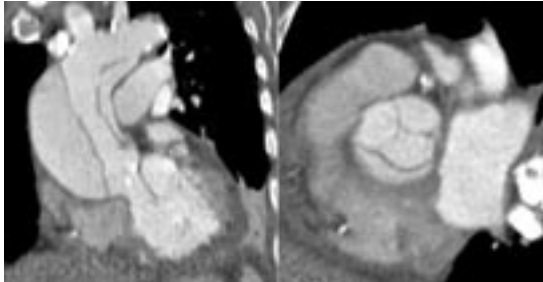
Coronal reformatted image (left) and oblique reformatted image (right) from contrast-enhanced, cardiac-gated computed tomography in a patient with acute aortic syndrome show a type A aortic dissection involving the aortic root, extending around the aortic valve, and aneurysmal dilatation of the aortic root.
